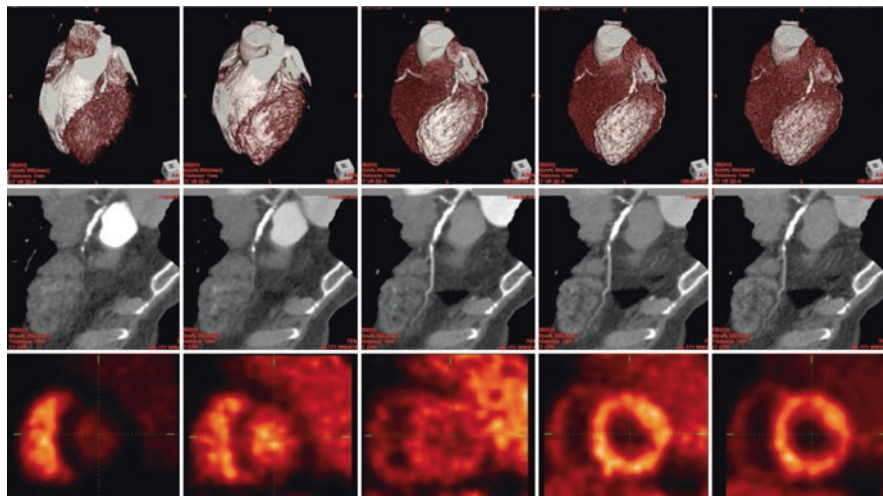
Serial images for dynamic CTA is shown. Dynamic 4D images of whole heart and coronary flow is visualised using motion coherence image processing technique. This technique is based on image interpolation of scanned images up to four times. Dynamic images were made from 20 scans of diastole phase with low tube voltage. Volume rendering and CPR are also available for measurement of intracoronary or intramyocardium time density. Lower panel shows dynamic scan for myocardial perfusion with N-13 ammonia PET
